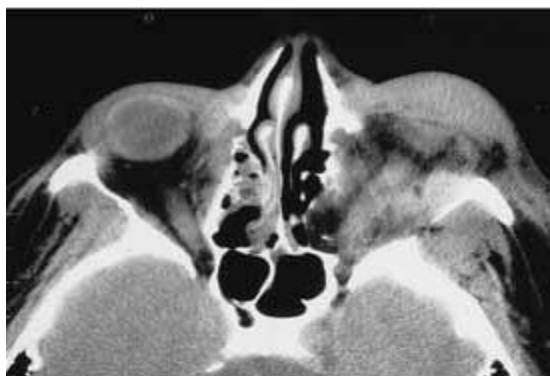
plain CT show increased and heterogenous attenuation with few air foci in the preseptal and retrobulbar compartments – orbital hemorrhage
